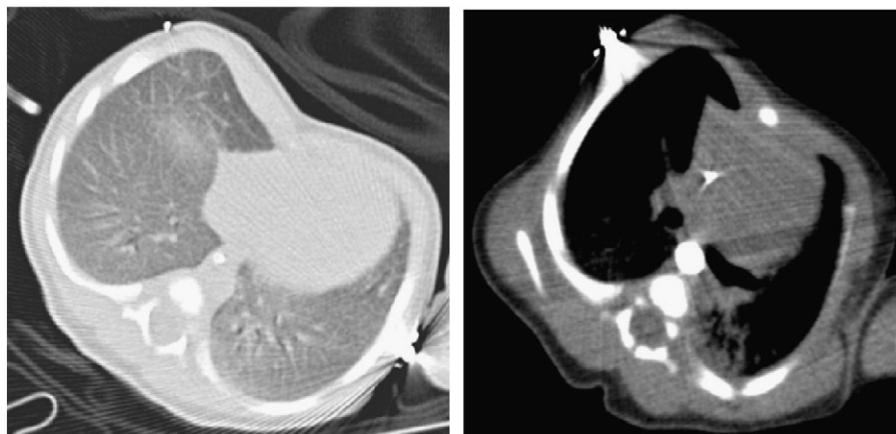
CT scan at 13 days of life.
